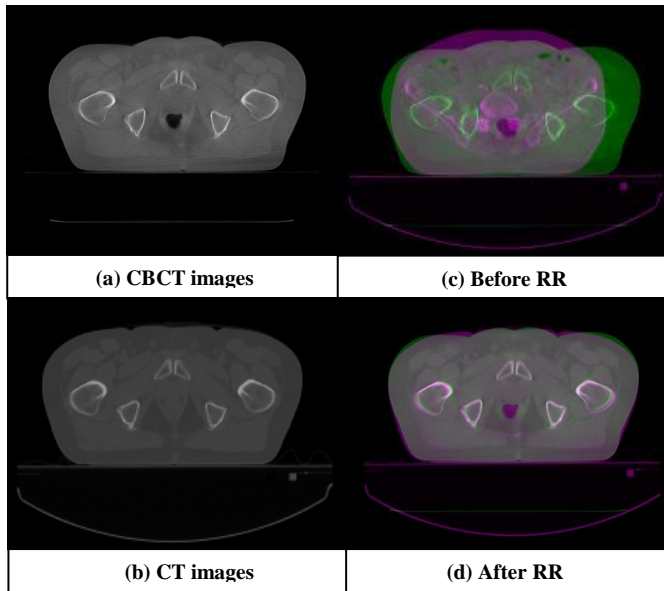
A slice of cone-beam CT (a) and the planning CT (b) and the results of superimposition of CT & CBCT before alignment (c) and after alignment (d) with rigid registration
